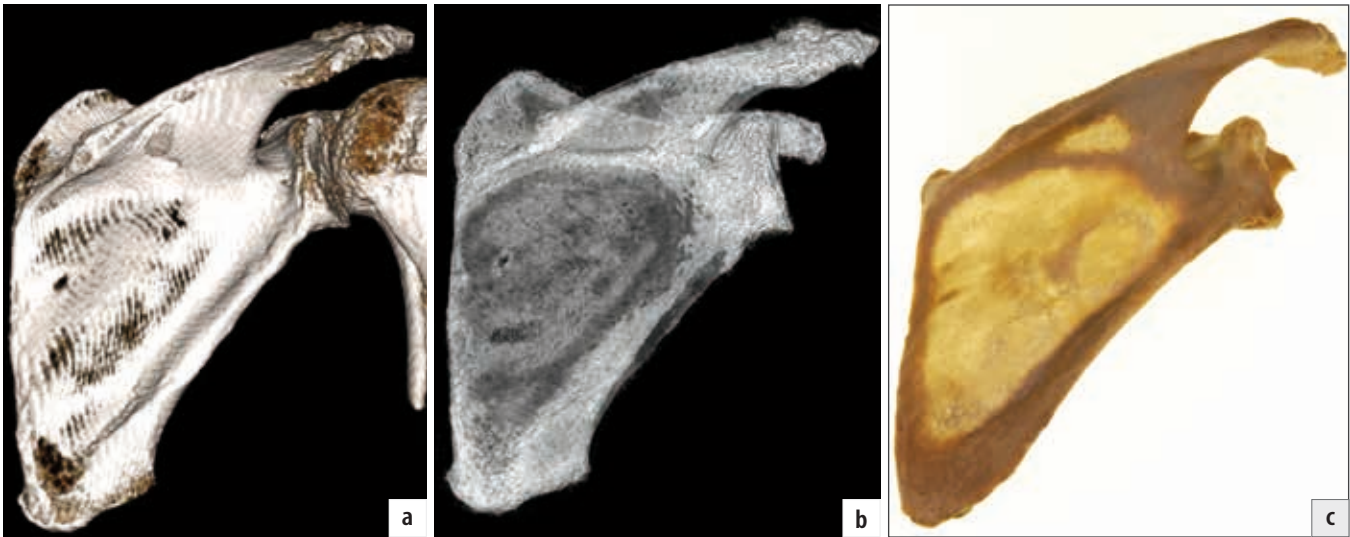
Pillars of the scapula – posterior view: a) 3D CT reconstruction of scapula; b) semi-transparent 3D CT reconstruction of scapula; c) transilluminated scapula.
